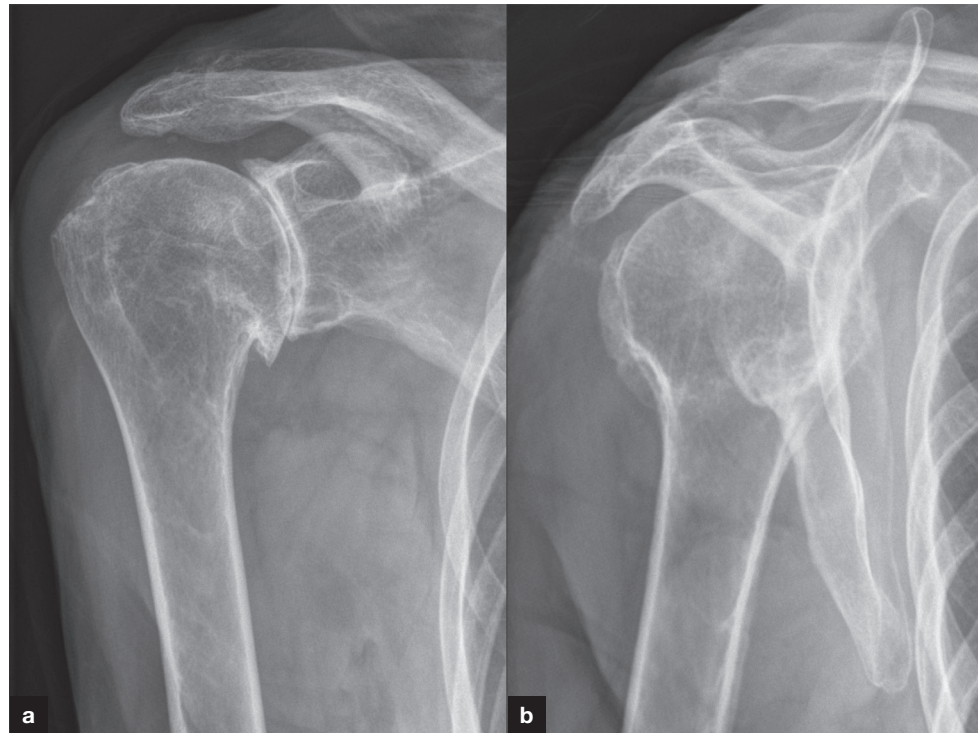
a. Antero-posterior and (b) lateral X-rays of the right shoulder demonstrate osteoarthritic changes, as evidenced by loss of joint space, subchondral sclerosis, subchondral cysts and osteophyte formation.
